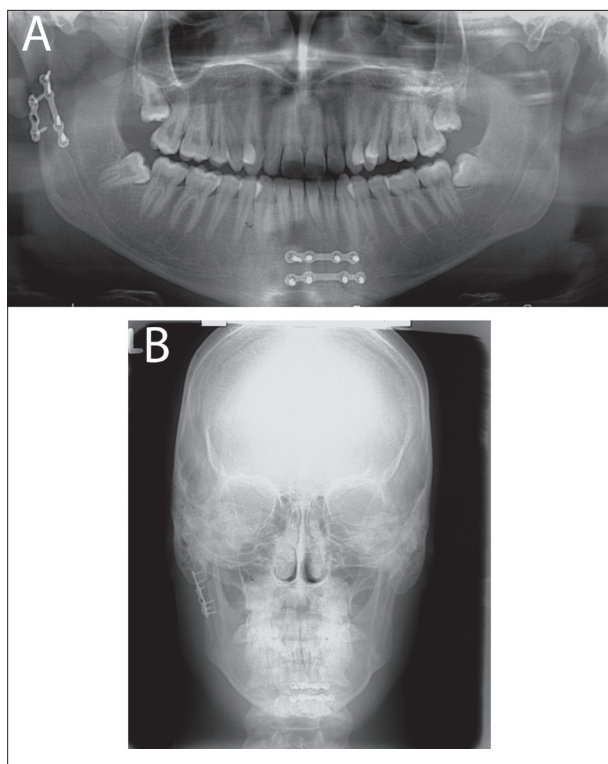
a) Postoperative orthopantomogram; b) Postoperative postero-anterior radiogram
